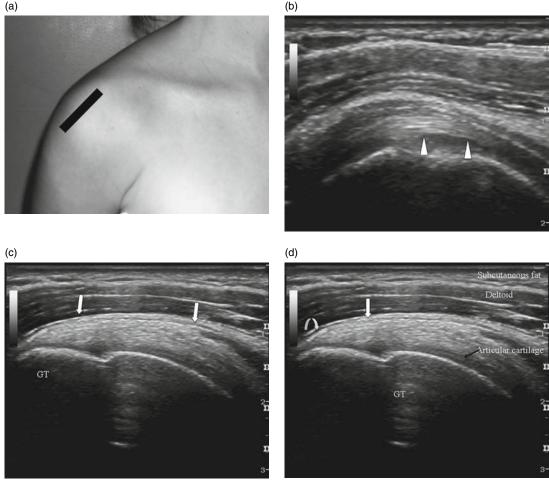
Supraspinatus tendon (arrows): (a) transducer position and corresponding (b) longitudinal ultrasound image of the intraarticular portion long head of the biceps tendon (arrowheads) at the rotator cuff interval. (c) The longitudinal ultrasound image demonstrating the hyperechoic fibrillar pattern of the supraspinatus is achieved by slowly moving the transducer posteriorly in the same plane. (d) Surrounding structures. GT, greater tuberosity; black arrow, articular cartilage; curved arrow, hypoechoic SASD bursa and adjacent hyperechoic capsule and peribursal fat.
